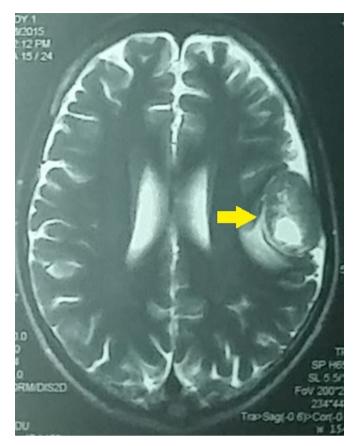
Cranial MRI with gadolinium showing a well-defined, extraaxial, heterogeneously enhancing solid mass in the left parietal area with central necrosis measuring 3.4×2.6×3.7 cm (as pointed by an arrow).
